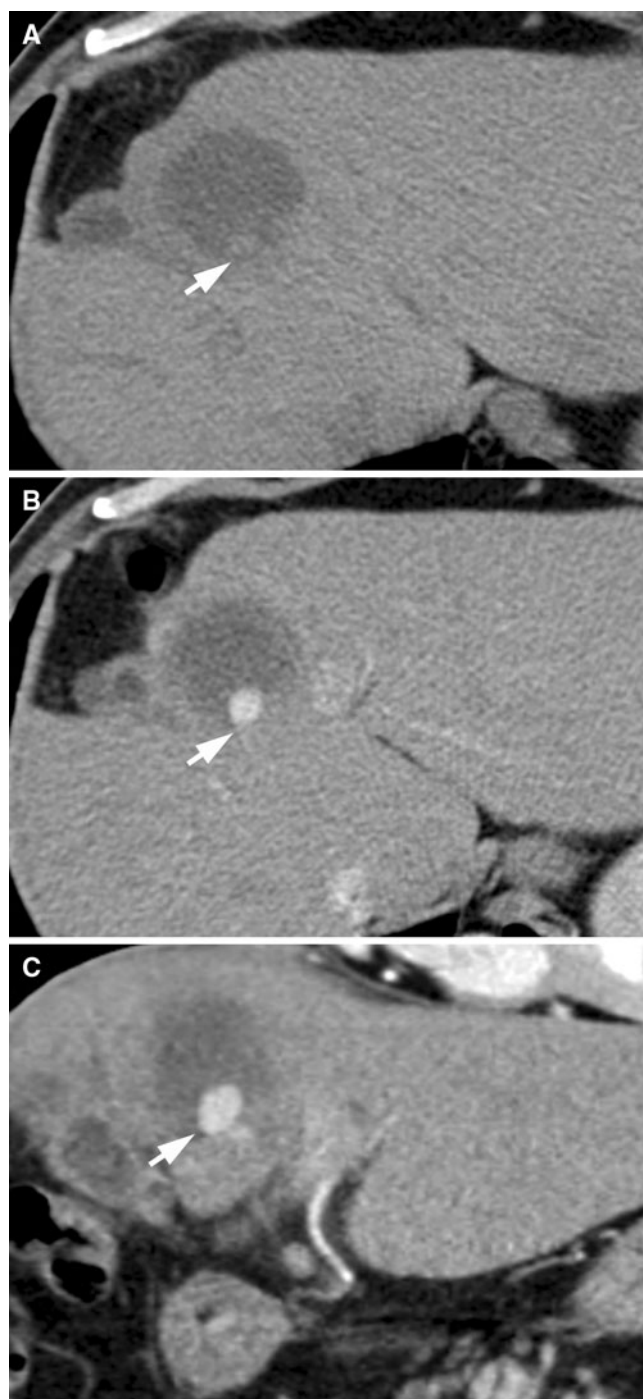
HCC treated with TACE. A CT scan before and B after intravenous contrast administration on axial and C coronal planes show a residual solid area in the periphery that enhances suggesting residual tumor (*arrows*).
